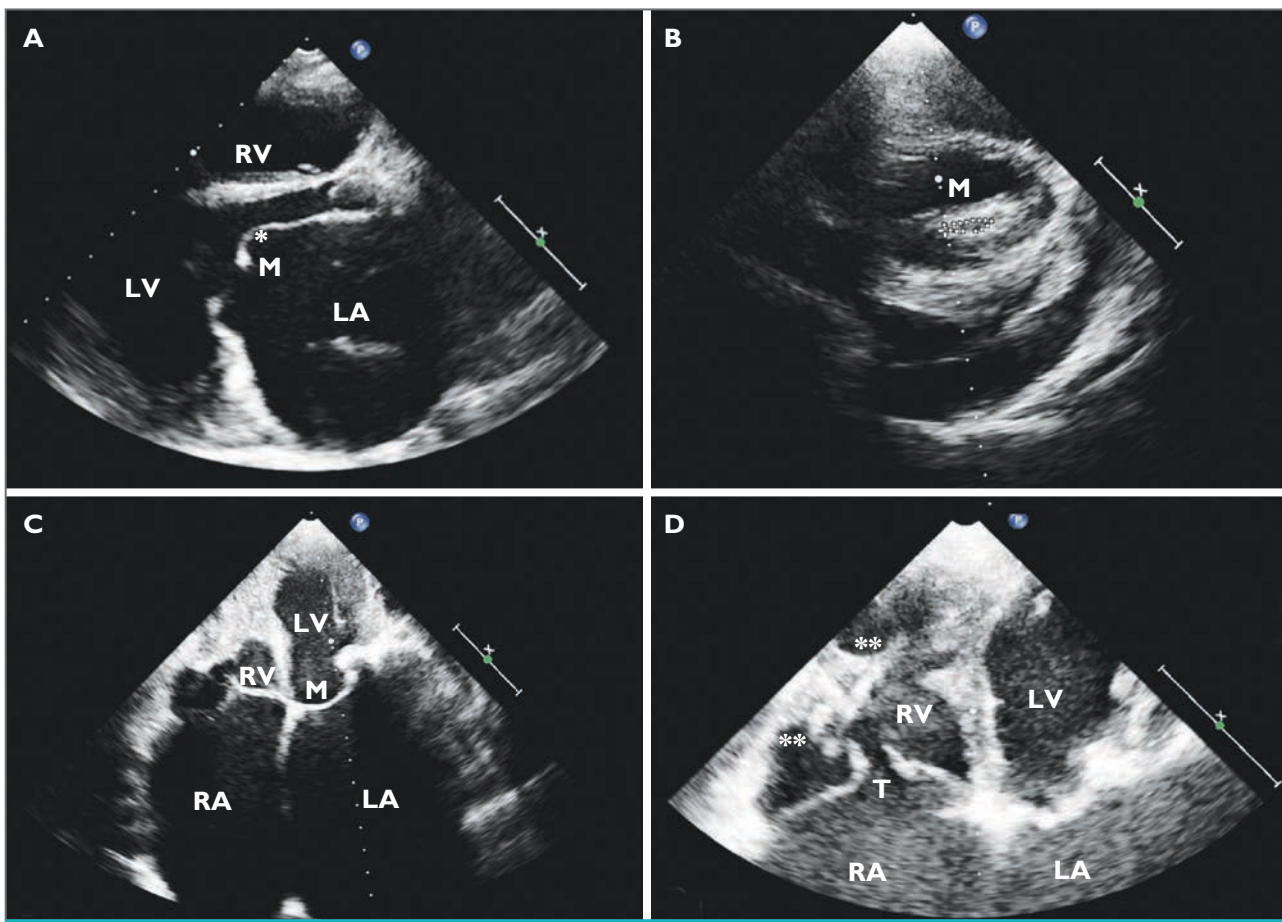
2D echocardiogram in parasternal long axis view with markedly enlarged left atrium (LA).The mitral valve (M) had a restriction of both leaflets with thickening at the tips of leaflets strongly suggesting a rheumatic heart valve disease.
